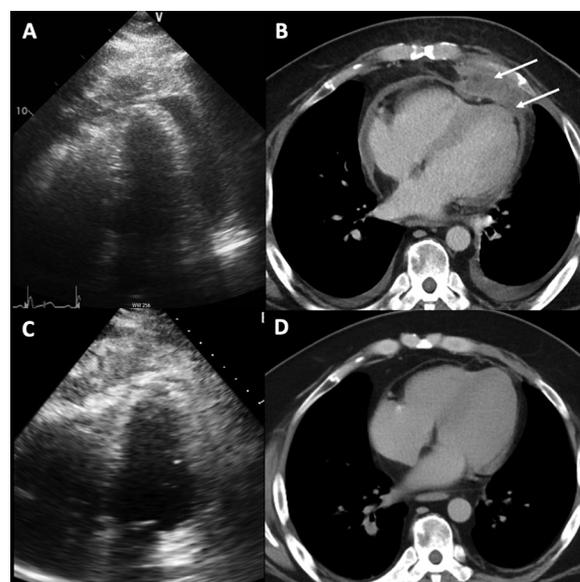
(A) Echocardiogram before pericardiocentesis demonstrating large pericardial effusion with mixed echogenic density structure surrounding the cardiac apex. (B) Computed tomography (CT) of the thorax showing complex structure (upper arrow) with thick rim enhancement and internal mixed density fluid component centred at the cardiac apex involving the pericardium (lower arrow), measuring 2.9x8.4x6.4cm. This favours an abscess. (C) Repeat echocardiogram after pericardiocentesis. (D) Repeat CT of the thorax 6 months post-drainage showing resolution of pericardial abscess.
